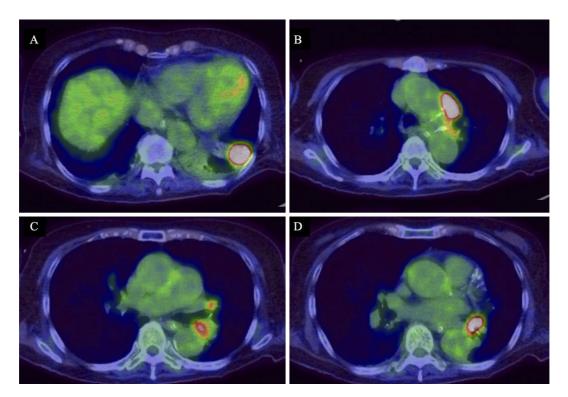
A PET-CT scan of the patient, which revealed para-aortic and left interlobar metastasis of primary lung cancer. In the primary focus (A), para-aortic metastasis (B), and left interlobar metastasis (C, D), hypermetabolic activities were seen.
